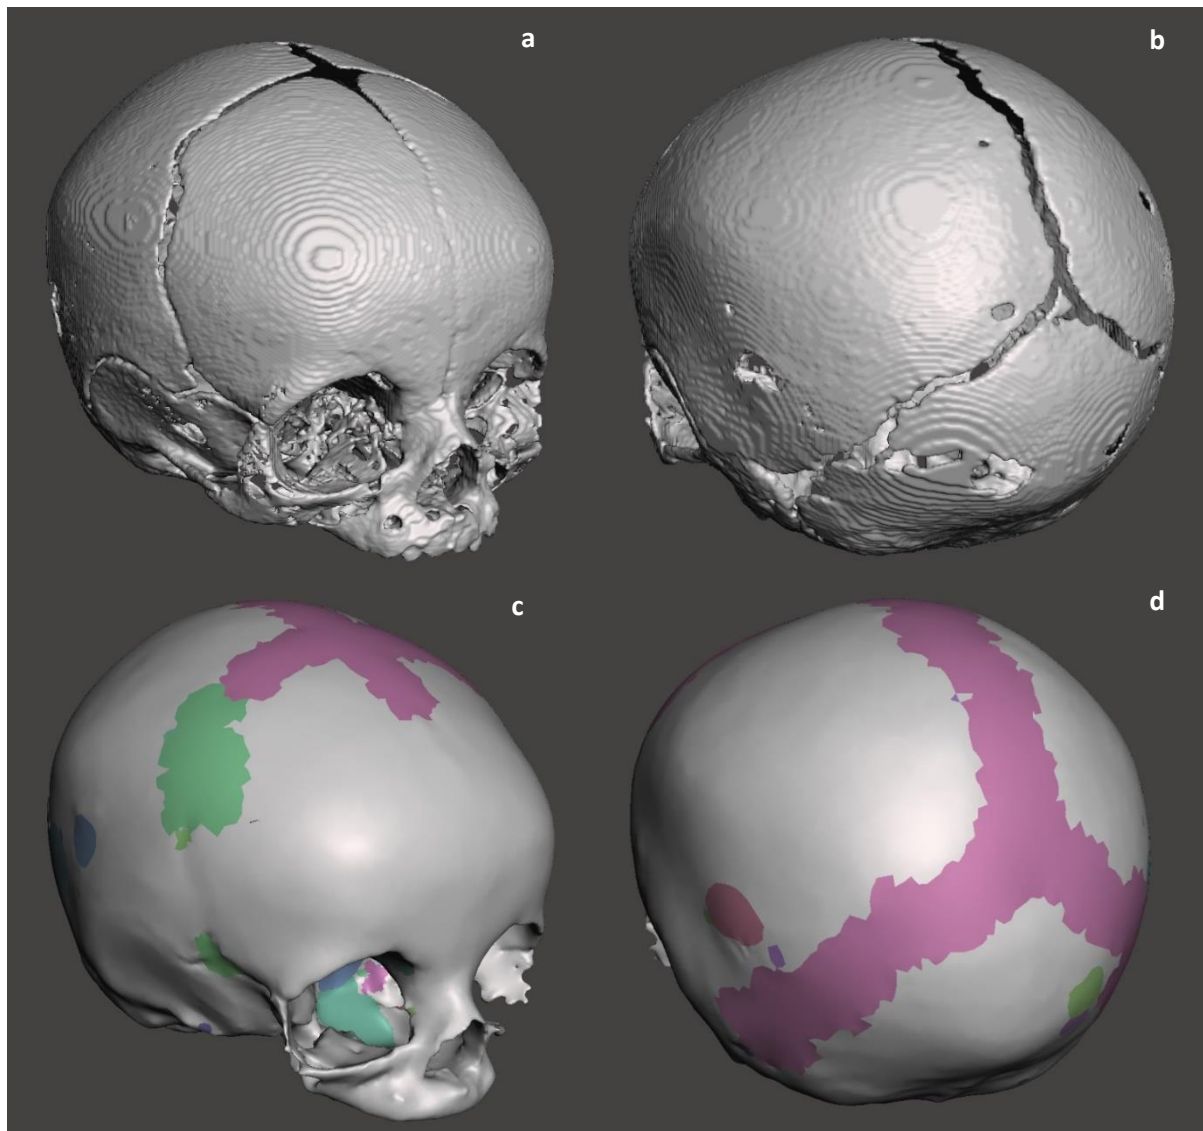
Skull geometry as segmented from CT scan ((a) and (b)), and after smoothing and patching of suture and holes ((c) and (d)). Note: patch colouring here does not mean anything.
